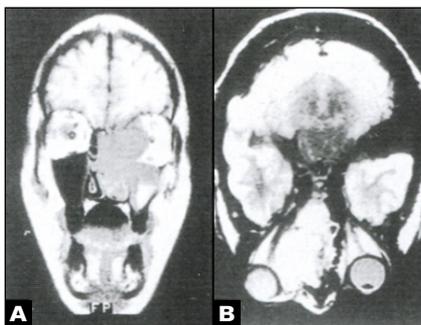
Radiographic appearance of rhabdomyosarcoma. (A) Large tumor involving left orbit and ethmoid sinus and eroding through base of skull. This patient was treated for sinusitis for one month before the correct diagnosis was made. (B) The tumor caused significant proptosis and nasal congestion. In cases like this, it may be difficult to distinguish the primary site of origin.
